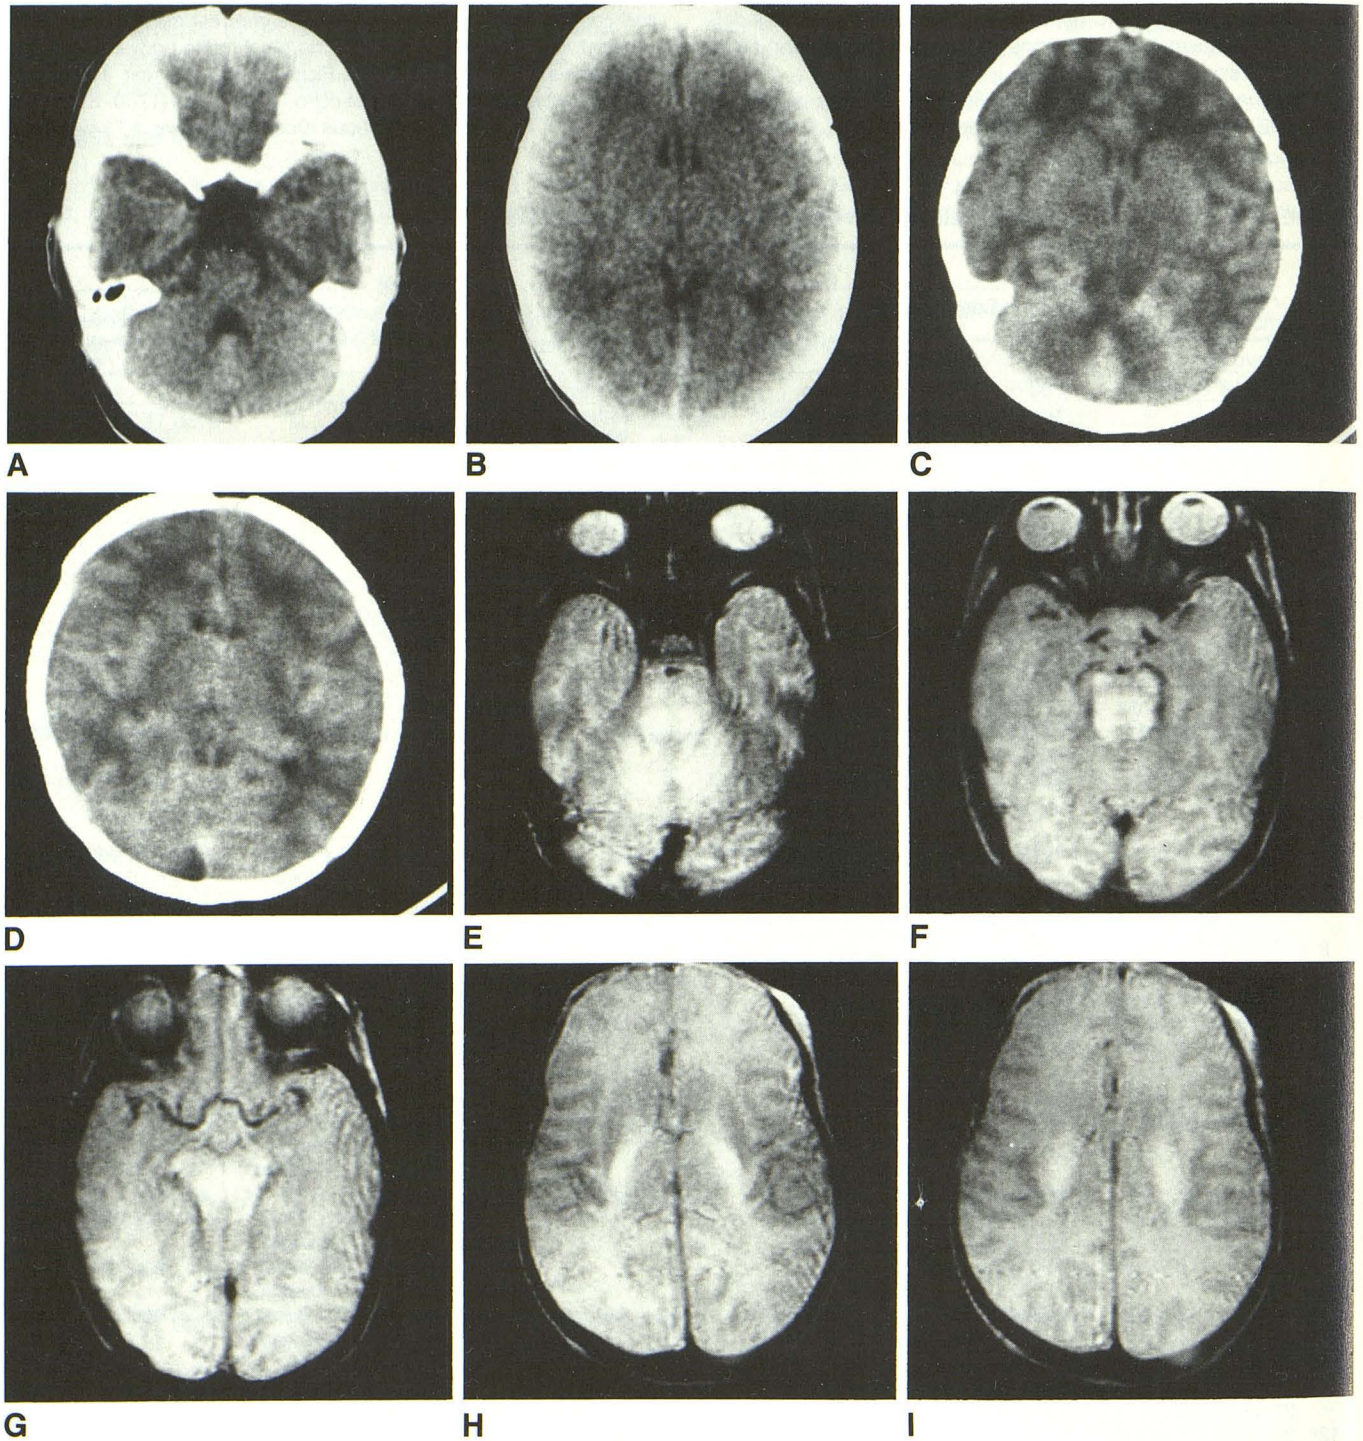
Case 9: Infant boy with hereditary maple syrup urine disease (MSUD). *A* and *B*, CT scans at age 3 days, before any symptoms had developed, are normal for age.
